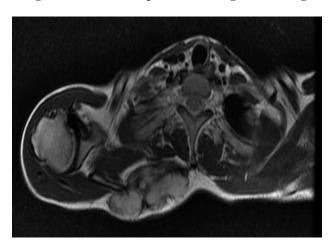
MRI showing large ill-defined mass in the subcutaneous plane in postero-superior aspect of right scapula.
